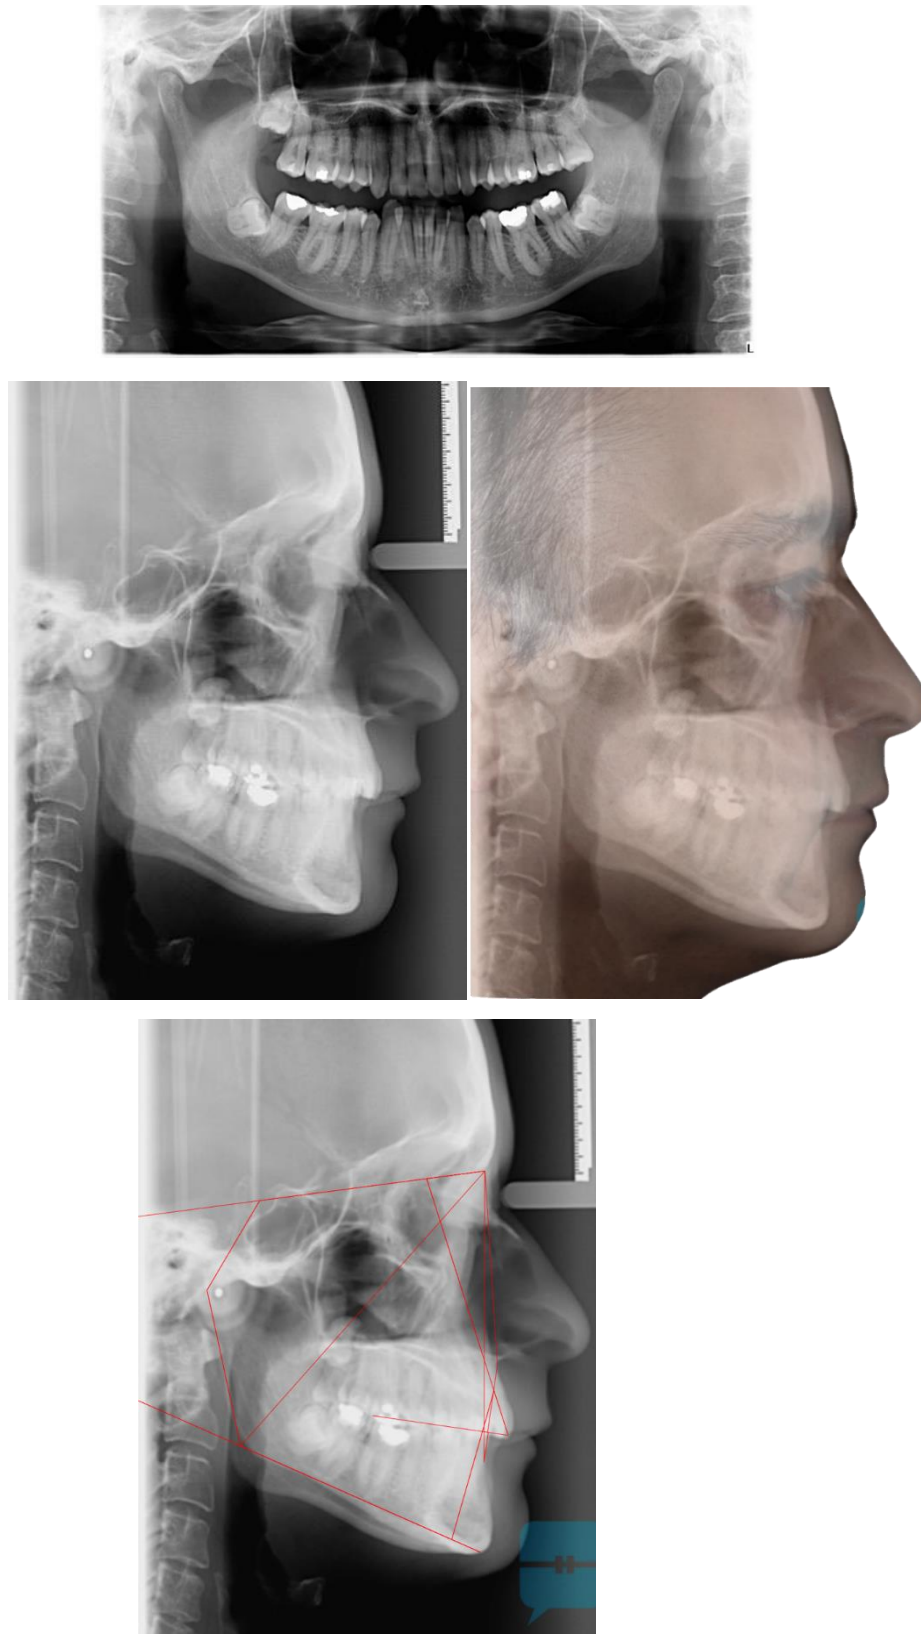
Pre-treatment radiograph and cephalometric analysis.
